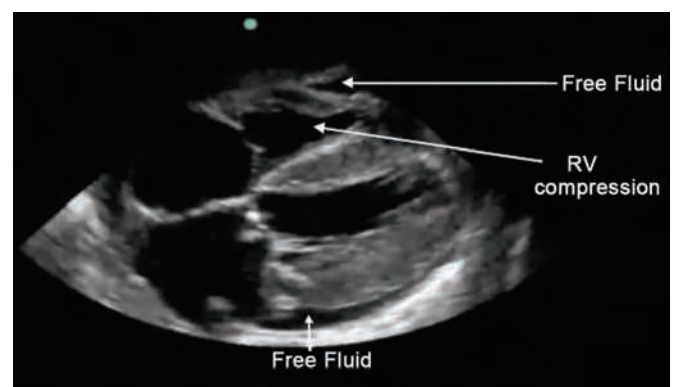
Ultrasound image of cardiac tamponade
